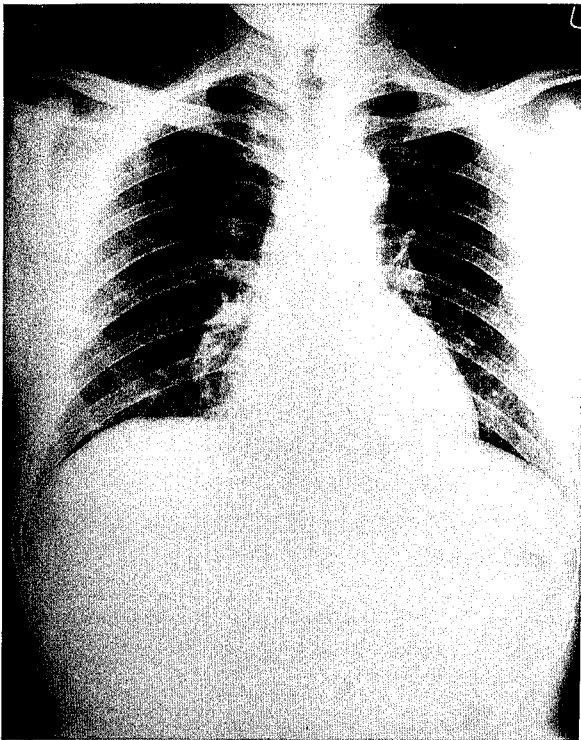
The chest radiography taken 7 years ago was normal.
